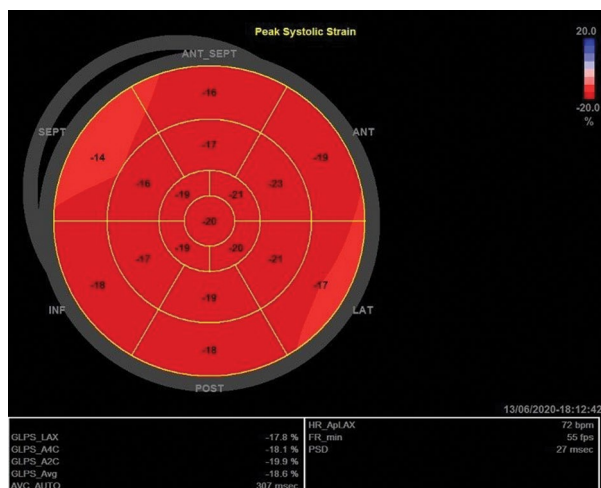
Left ventricular longitudinal strain bull's eye plot derived from the two-dimensional (2D) speckle tracking imaging in echocardiography performed two years after pacemaker implantation (GE Healthcare, Chicago, Illinois, USA)
